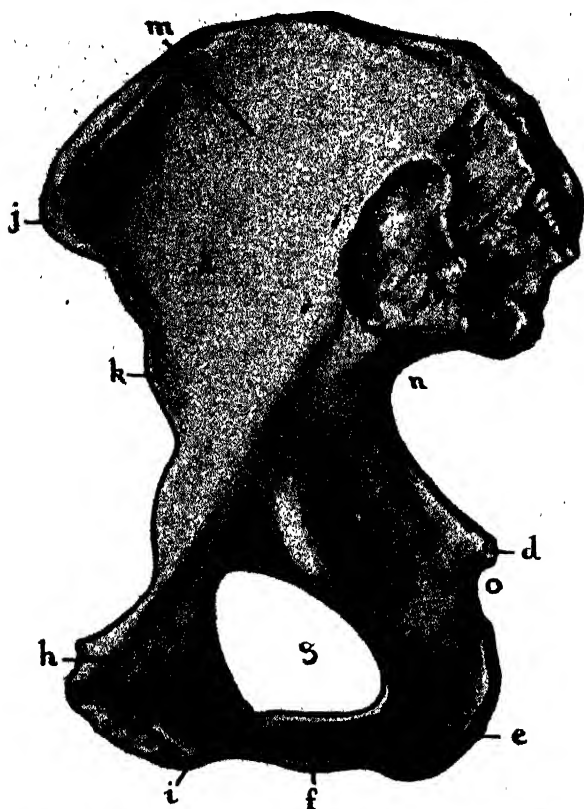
THE RIGHT OS INNOMINATUM. INTERNAL ASPECT.
